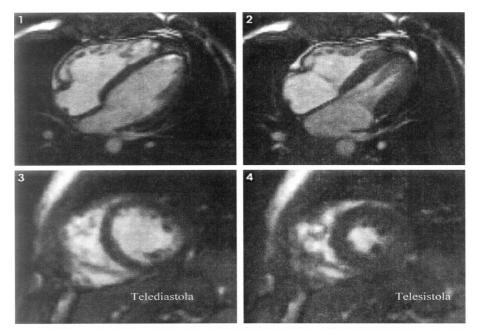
Cardiac MRI examination: end-systolic images (1.2) in apical four chambers section (1.2) shows a dilated right heart with an enlarged right ventricle that is restricted by the sternum during contraction, resulting in a fold of the free wall, and end diastolic images(3.4) in parasternal short axis section, is observed the left ventricle noncompaction and the presence of trabeculae in the LV wall.
